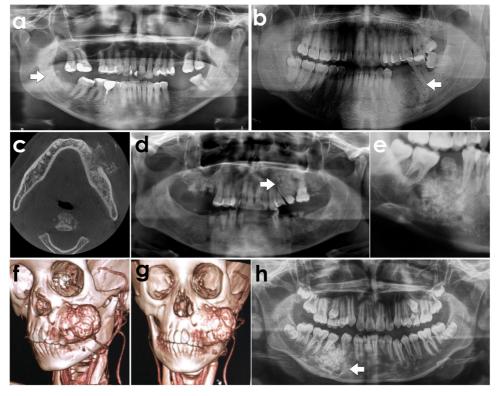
Radiographic and computed tomography (CT) images of epithelioid osteoblastomas. Epithelioid osteoblastomas produced a mixed radiolucent—radiopaque image with ill-defined borders in cases 1 (A) and 2 (B, C). Case 3 (D) showed tooth root displacement and well-defined limits. Case 4 (E) exhibited a mixed and ill-defined image in the previously extracted first molar site. A 3-dimensional reconstruction from the CT scan of case 5 (F, G) showed a large expansive lesion in the alveolar maxillary process. The mixed image in case 6 (H) showed the lesion surrounded by a sclerotic margin.
